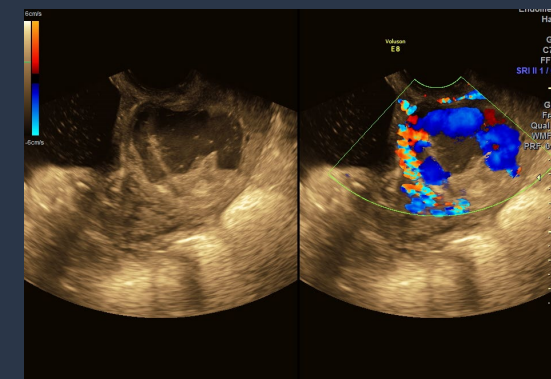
transvaginal colour Doppler ultrasound of abnormal vasculature.
